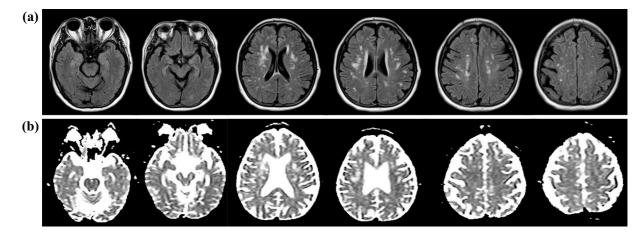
(a) Fluid-attenuated inversion recovery and (b) apparent diffusion coefficient magnetic resonance imaging sequence showed high-signal areas in some of the high-signal regions shown on diffusion-weighted imaging.
